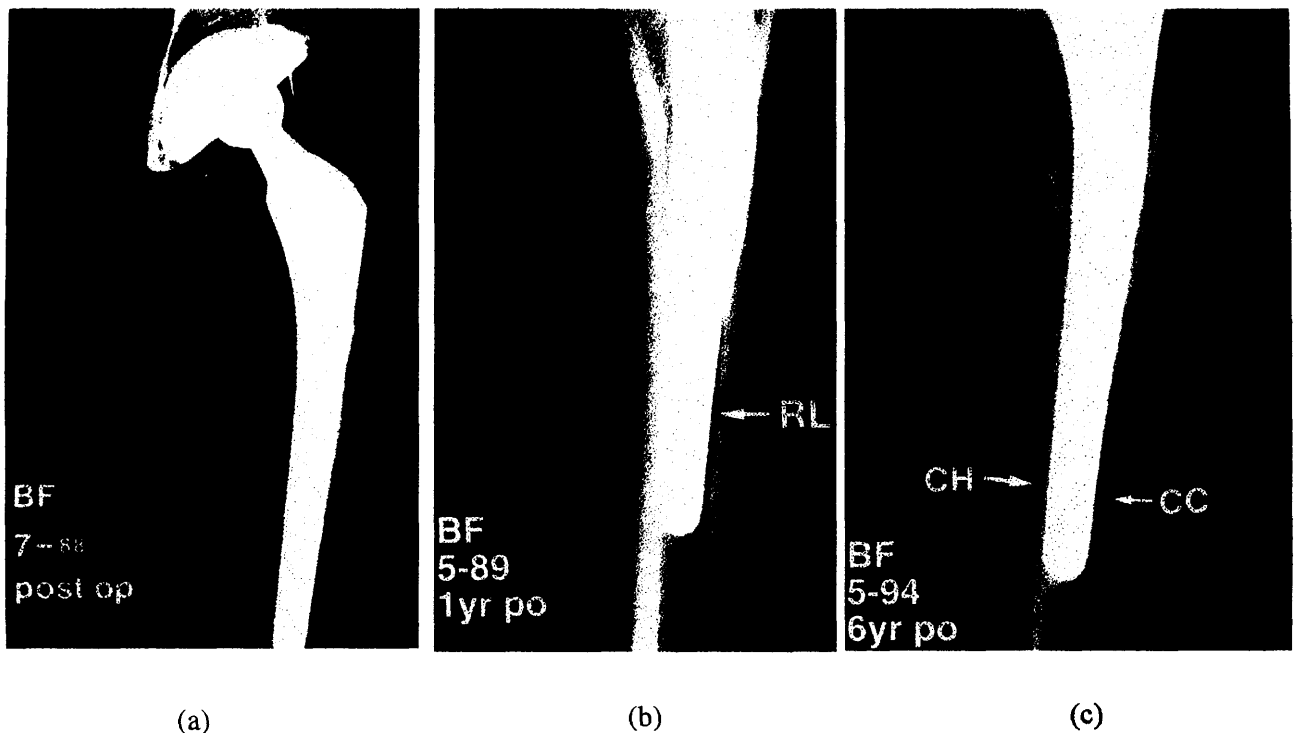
Radiographs of a 25-year-old man who had avascular necrosis of the left hip. (Courtesy of Capello et al.¹¹) (a) Early postoperative anteroposterior radiograph. (b) Close-up radiograph, made 1 year postoperatively, showing evidence of a radiolucent line around the distal part. (c) Close-up radiograph, made 6 years postoperatively, showing areas of cancellous condensation and cortical hypertrophy, but no evidence of radiolucent line around the distal part.
